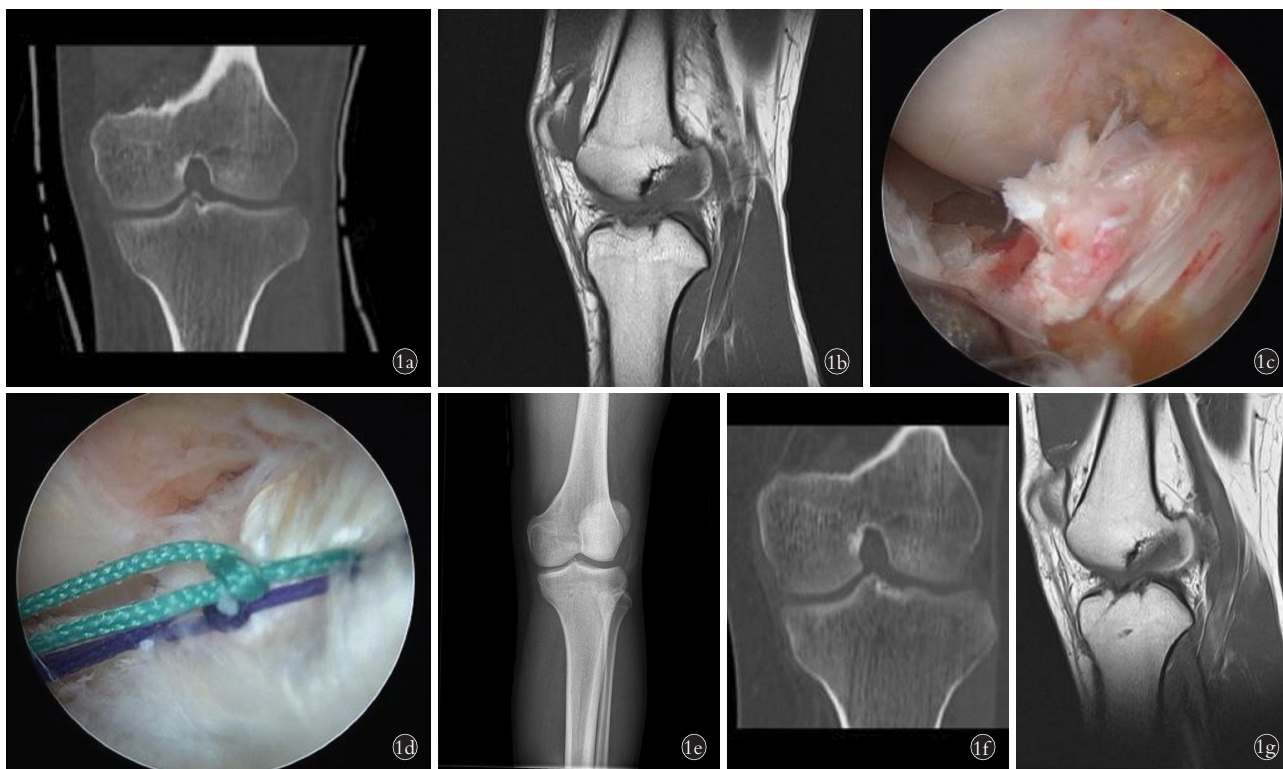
患者,男,22 岁,左 Meyers-McKeeever II 型前交叉韧带胫骨止点撕脱骨折 1a. 术前冠状位 CT 示左胫骨止点撕脱骨折 1b. 术前矢状位 MRI 示左前交叉韧带胫骨止点撕脱骨折 1c. 术中关节镜下见左前交叉韧带胫骨止点撕脱骨折 1d. 术中关节镜下见高强度线固定情况 1e. 术后正位 X 线片示左胫骨止点撕脱骨折复位情况 1f. 术后 6 个月冠状位 CT 示骨愈合情况 1g. 术后 6 个月矢状位 MRI 示骨愈合情况
